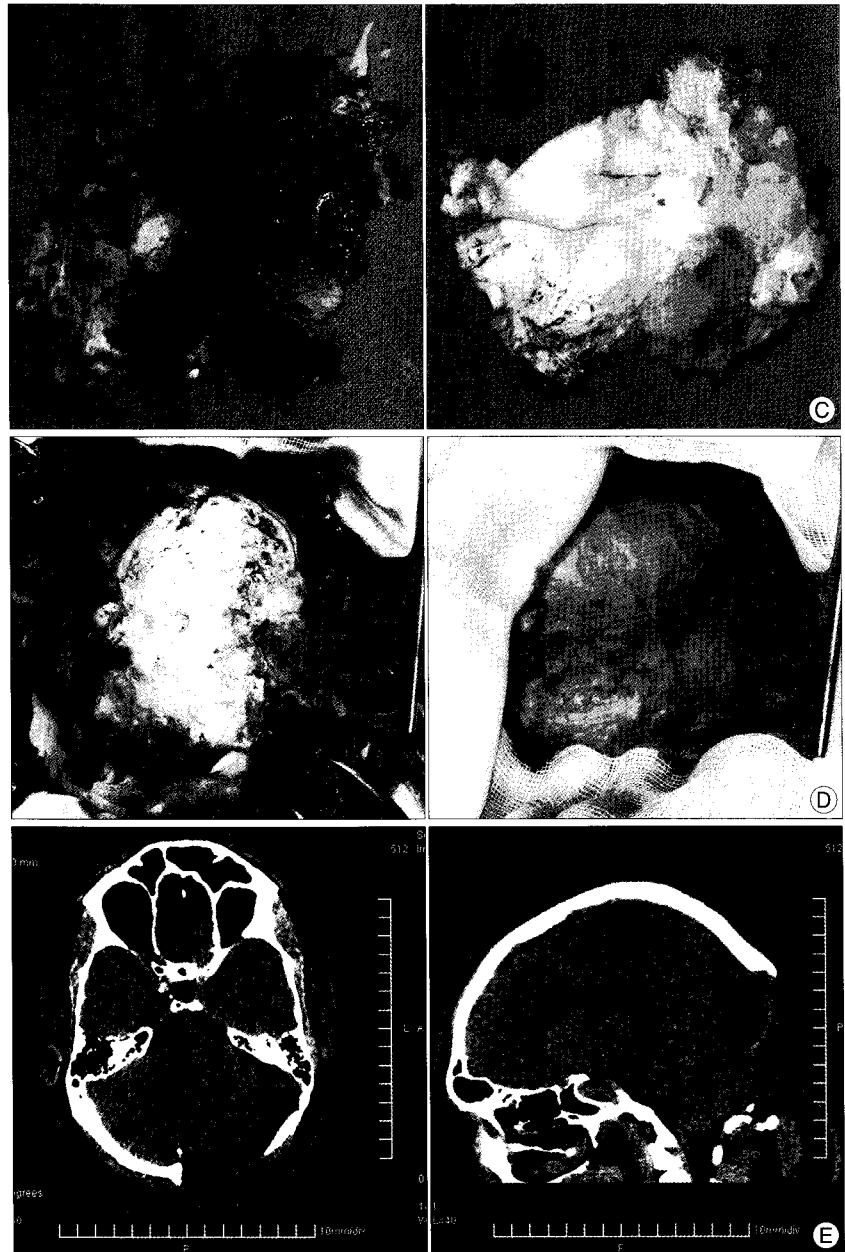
Continued. C : Note the removed occipital bone which is widely destroyed, thinner and partially perforated by the tumour. D : Note the tumor which is soft, whitish and cheesy (left). The dura mater over the cerebellum is thickened and intact throughout (right). E : Postoperative CT scans one day after the procedure show total removal of the tumor.
